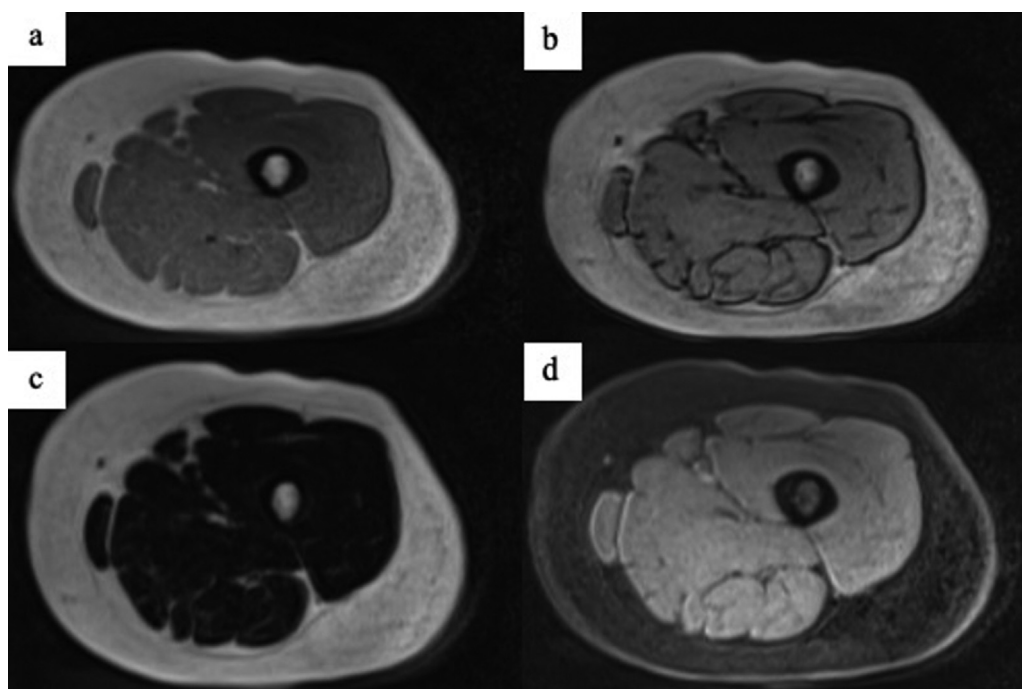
Dixon MRI sequence of the right thigh in a 64-year-old woman. Axial T1W in-phase (a), out-of-phase (b), 100% fat images (c), and 100% water images (d) are shown. The images depict reduction in the muscle bulk with fatty infiltration of the muscles (as seen by chemical shift artefact on out-of-phase image). These findings are suggestive of myosteatorsis and sarcopenia. MRI, magnetic resonance imaging.
